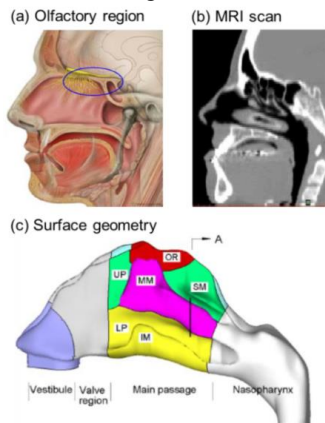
Nasal airway physiology: (a) anatomy; (b) MRI scan; and (c) surface model geometry.
